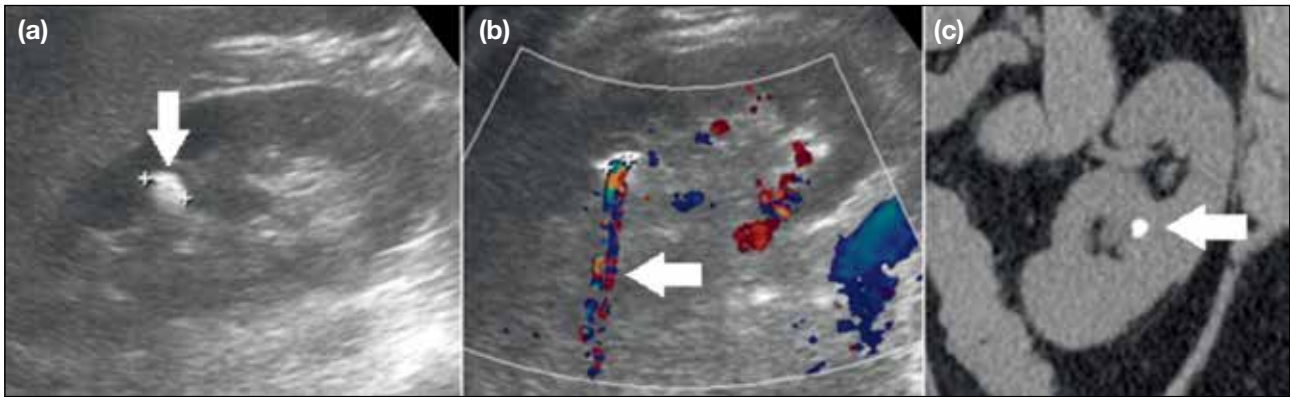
A 66-year-old woman with left flank pain. (a) Ultrasonograph showing echogenic focus (8 mm) with posterior acoustic shadowing (arrow) in the left kidney. (b) Colour Doppler ultrasonograph showing corresponding twinkling artefact (arrow). (c) Diagnosis of left nephrolithiasis was confirmed by computed tomography (arrow).
